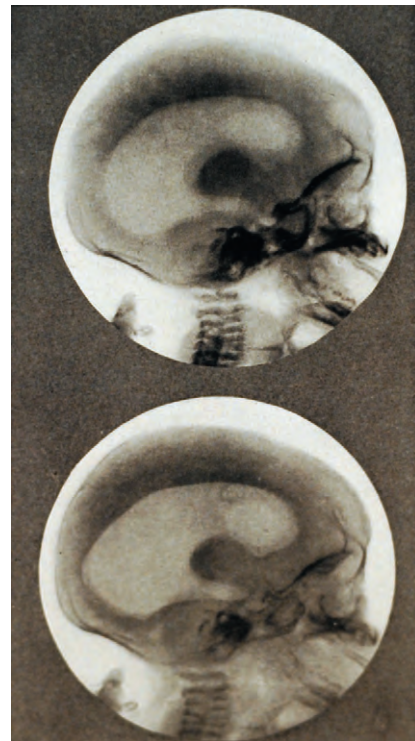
One of the landmark contributions to neurosurgery made by Dandy (and Blackfan), introduction of the pneumoencephalogram—a technique in which air was introduced into the ventricles and with a radiograph the ventricular system could be seen in outline.
